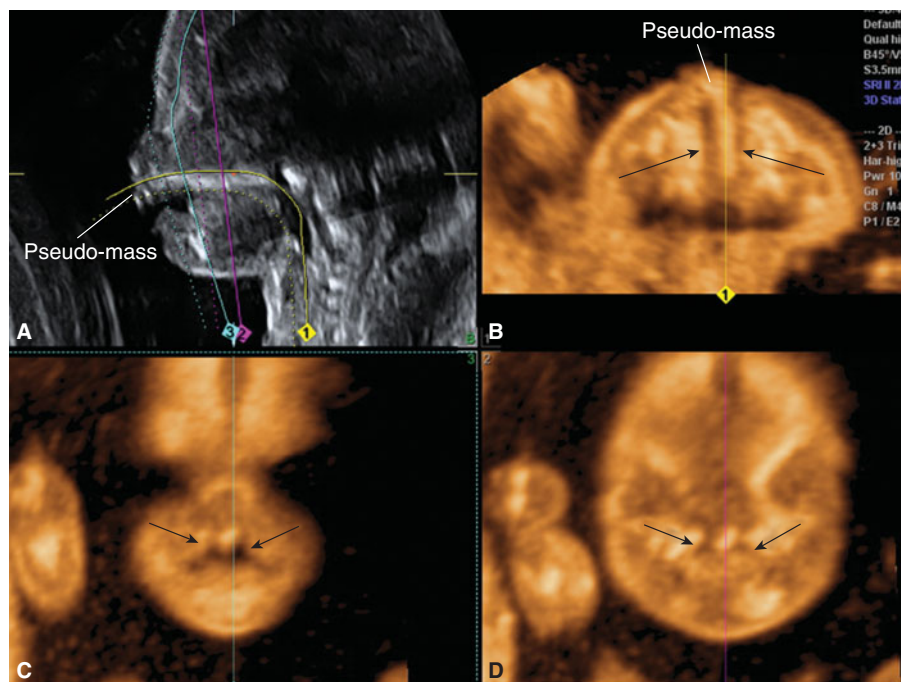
Bilateral cleft lip/palate (arrows) demonstrated with multisectional analysis of a US volume. The anterior protrusion of the central portion of the maxilla in the sagittal (A) and axial (B) views results in a typical premaxillary pseudomass. Coronal sections (C–D) reveal the clefts extending into the palate (Reproduced, with permission, from Pilu G. *Atlas of Obstetric Ultrasound*, The Global Library of Women's Medicine, www.glowm.com.)
